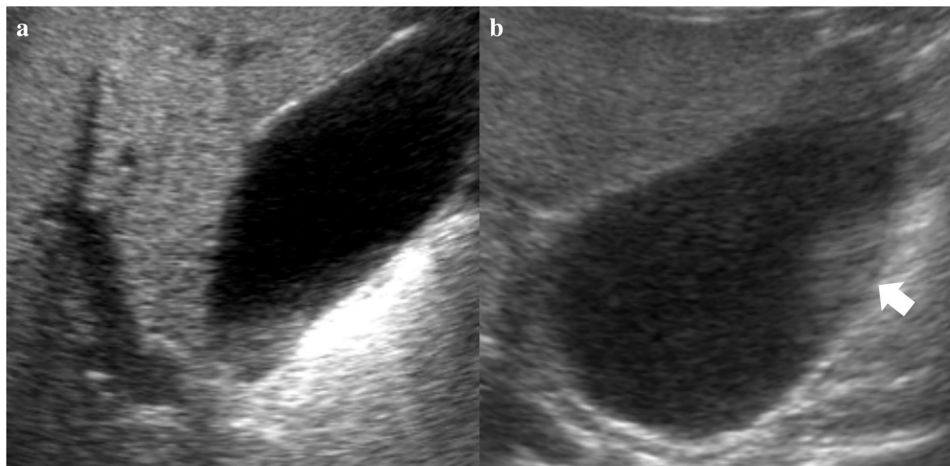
Ultrasound sonography revealed a high echoic area which appeared to be debris in gallbladder (a) and a 15-mm ellipse-shaped section of liver tissue (arrow) attached in front of the gallbladder (b).
